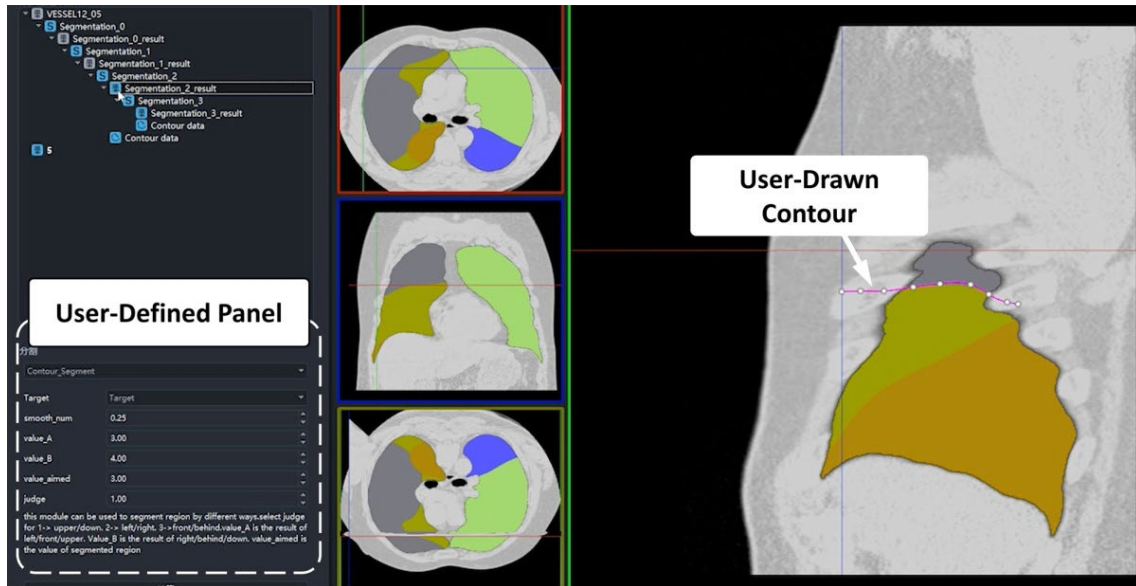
An example of a user-developed plugin module for lung lobe annotation in CT images
